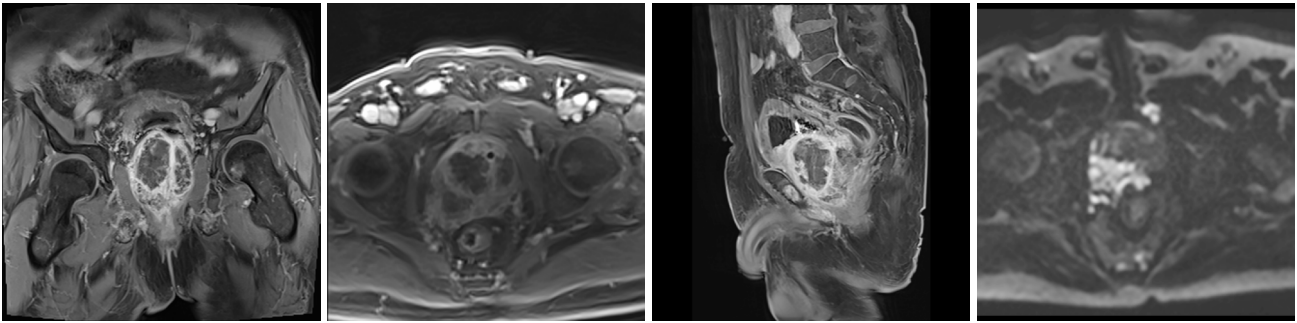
MRI findings at 1 week after the operation: PV was approximately 5.4 cm × 4.8 cm × 5.9 cm, the soft tissue mass shadow was slightly smaller than that in previous MRI findings, the high signal intensity of the DWI sequence was weaker than that in previous MRI findings, and the range was smaller than that in previous MRI findings. MRI, magnetic resonance imaging; DWI, diffusion-weighted imaging; PV, prostate volume.
